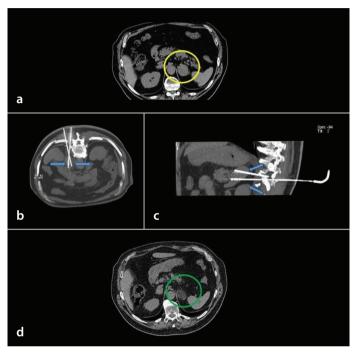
A 78-year-old woman with a history of non-small cell lung cancer with solid left adrenal metastasis [yellow circle in the preoperative computed tomography (CT) scan in a]. Treatment of the lesion with cryoablation using two Icesphere 1.5 cryoprobes (Visual ICE TM , Galil Medical-Boston Scientific, Arden Hills, MN, USA), via posterior percutaneous access (blue arrows in the intraoperative axial scan image in b and in the sagittal plane reconstruction in c). Complete necrosis of the lesion in the CT follow-up (green arrow in d).
